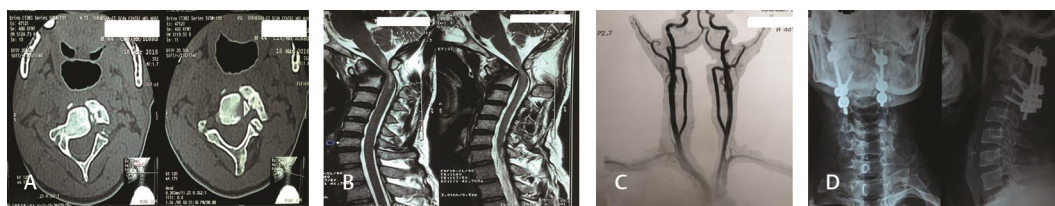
(A) Axial computed tomography of a patient with C2 comminuted fracture. (B) Magnetic resonance imaging of the same patient showing severe compression over craniocervical junction. (C) Computed tomography angiogram of the same patient done to delineate the course of vertebral artery. (D) Postoperative skiagram of the patient with occipitocervical fixation.
